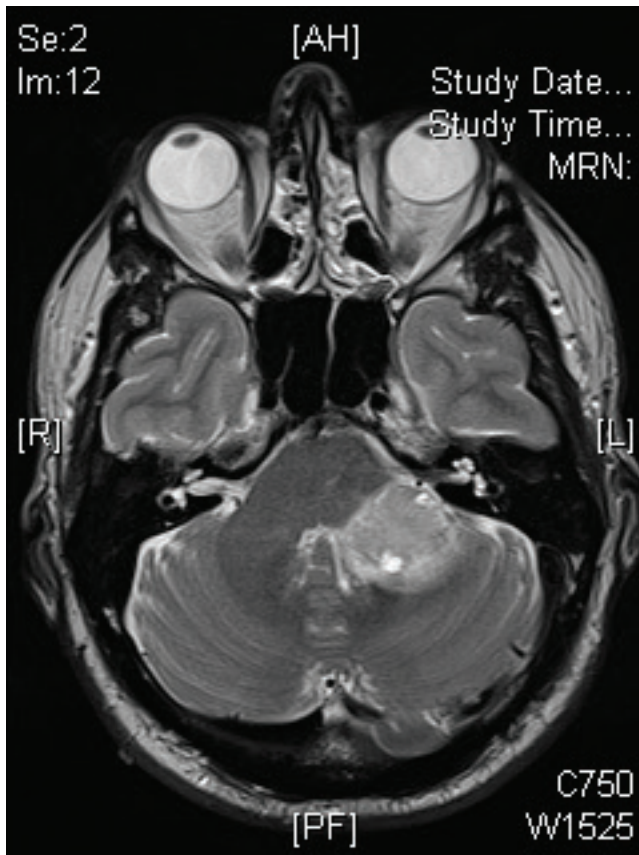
Axial T1- weighted MRI scan with gadolinium enhancement showing a left CPA metastasis.
